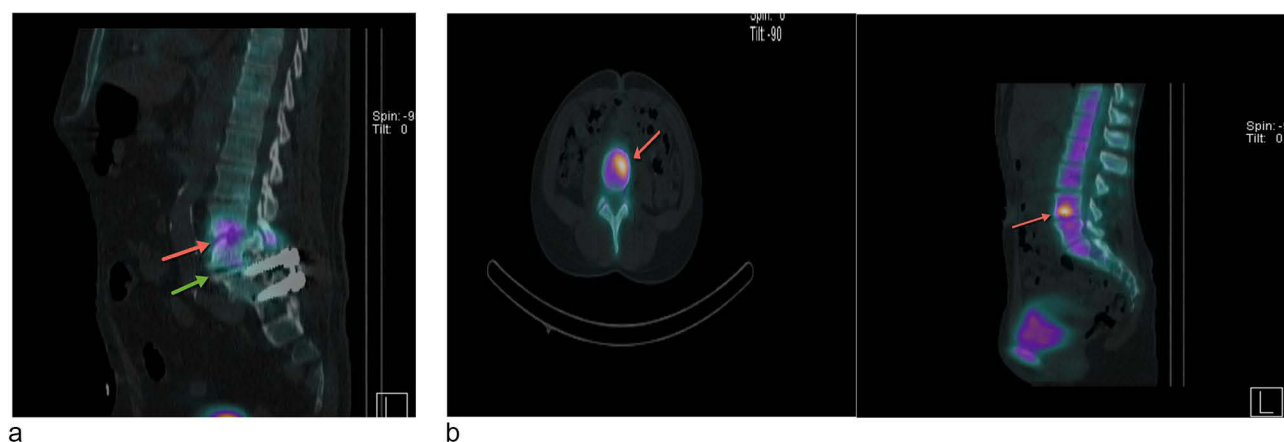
(a) SPECT CT image identifying area of pain generation due to disc degeneration. This was ruled out as infection by biopsy and subsequently treated with basivertebral nerve ablation the level above and below the disc with degenerative endplate change and radiotracer uptake (red arrow) generally associated with pain generator. Green arrow is an example of vacuum phenomena. (b) Use of SPECT CT to determine radiotracer uptake consistent with a pain generator (red arrows) in a patient concordant with mild Modic change on MRI (not shown) and treatment failure of posterior column interventions. Red arrow denotes uptake of tracer and suggesting highly metabolic zone consistent with potential pathology.
